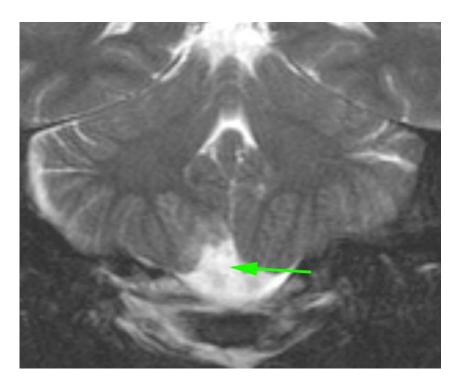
Postoperative T2 coronal MRI, revealing total removal of the tumor (green arrow) MRI: Magnetic resonance imaging.
